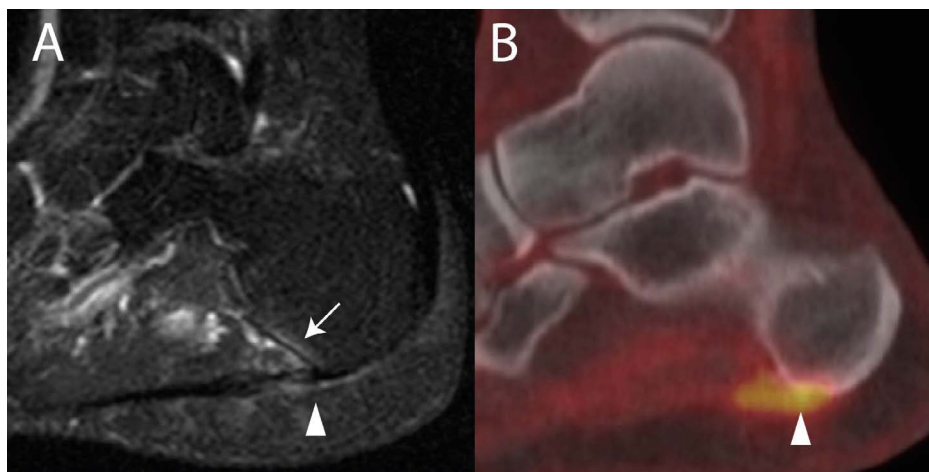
MRI and 18F-FDG PET/CT of a 54-year-old male with ankylosing spondylitis, showing abnormalities at the plantar fascia enthesis.
